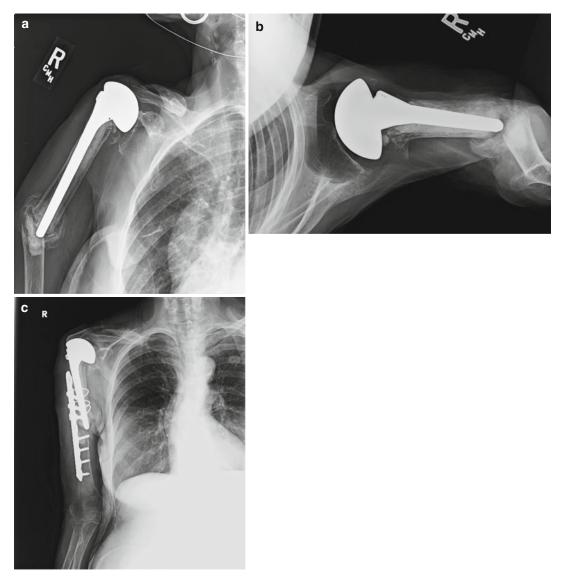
(a, b) AP and axillary views of a Type III periprosthetic humeral fracture. (c) Postoperative x-ray showing treatment with open reduction and internal fixation using hybrid fixation with screws and cerclage wires
